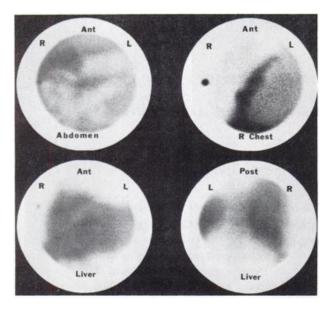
(Upper left) Anterior abdominal scintigram at 30 min after intraperitoneal tracer administration reveals widespread distribution of radioactivity except in several gas-filled loops of bowel. (Upper right) Right anterior chest view reveals tracer in subcutaneous tubing entering circulation through external jugular vein. Note diffuse background activity in pulmonary and cardiac blood pools. (Lower left and right) At 1 hr, clearly recognizable radioactive tracer throughout liver and spleen is demonstrated, indicating patent peritoneo-venous shunt. Dark spot at margin is radioactive source used to mark patient's right side.
